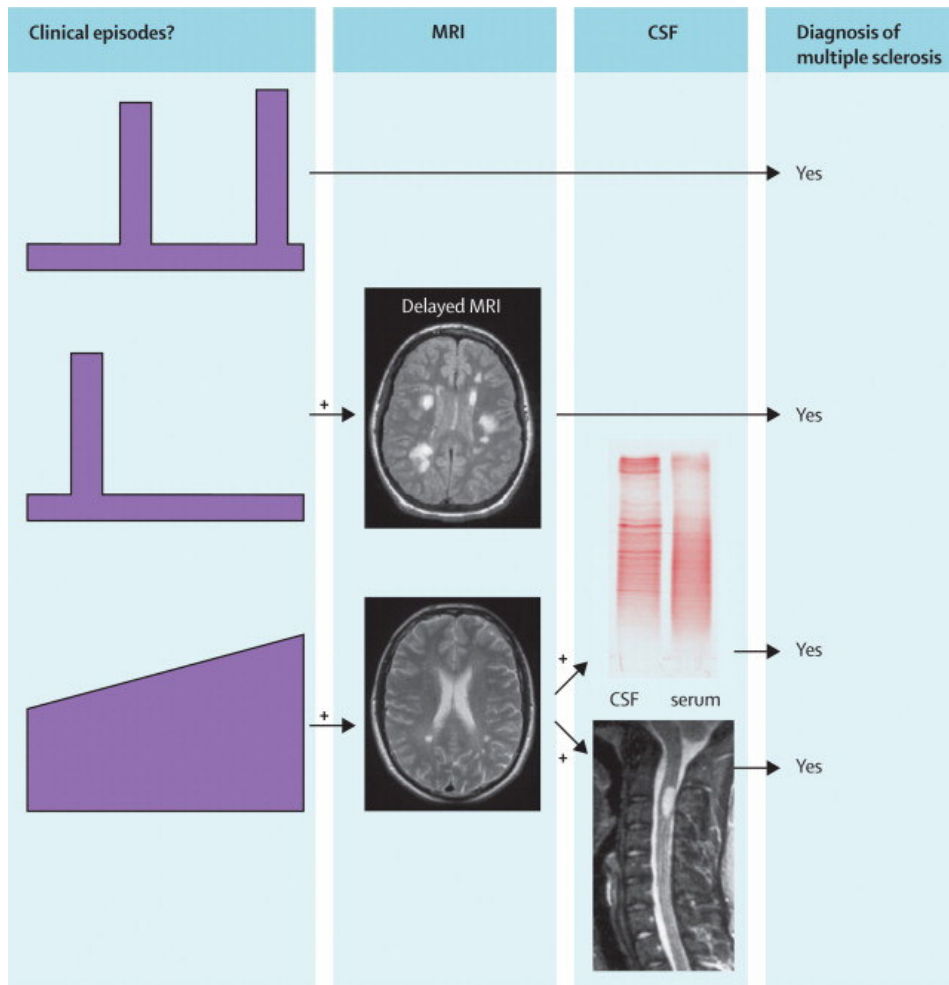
Criteria for the diagnosis of MS. Modified from the McDonald criteria (Polman et al., 2011). The principle is to establish dissemination in time and place of lesions (i.e. episodes affecting separate sites within the CNS have occurred at least 30 days apart). MRI can substitute for one of these clinical episodes. Dissemination in time of magnetic resonance lesions requires: one gadolinium-enhancing lesion at least 3 months after the onset of the clinical event; or a new T2 lesion compared with a reference scan done at least 30 days after onset of the clinical event. In the case of recurrent stereotyped clinical episodes at the same neurological site, criteria for MRI definition of dissemination in space are three features from: (1) one gadolinium-enhancing lesion or nine T2 MRI lesions; (2) one or more infratentorial lesions; (3) one or more juxtacortical lesions; or (4) three or more periventricular lesions; (a spinal cord lesion can replace some of these brain lesions). Primary progressive MS can be diagnosed after 1 year of a progressive deficit and: (1) a positive brain MRI; (2) a positive spinal cord MRI; and (3) positive oligoclonal bands. Patients having an appropriate clinical presentation, but who do not meet all of the diagnostic criteria can be classified as having possible MS. Adapted from Compston & Coles (2008).
